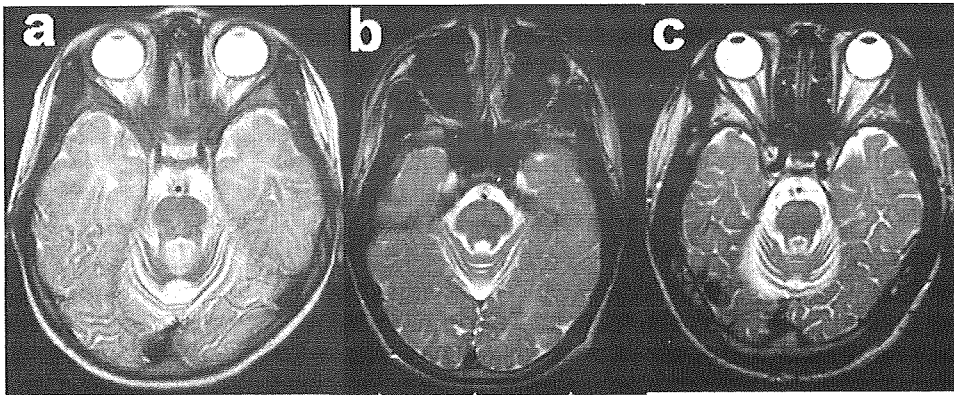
T2-weighted axial MRI at the cerebellopontine level (a: patient 1; b: patient 2; c: patient 3). The cerebellar cortex is atrophic, and normal signal intensity can be seen in all three cases. Pons is slightly atrophic, but myelination appears normal in all cases.
